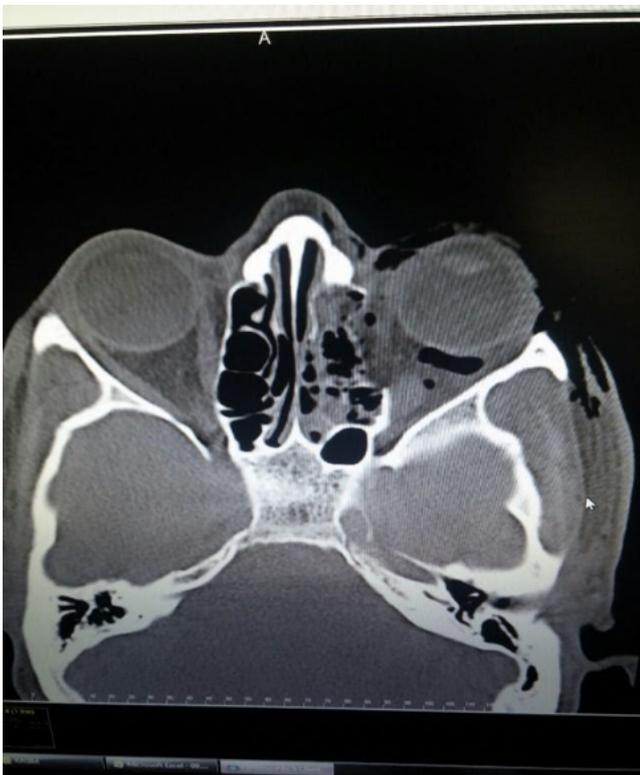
CT scan of the paranasal sinuses showed fracture which included the lamina papycea.
